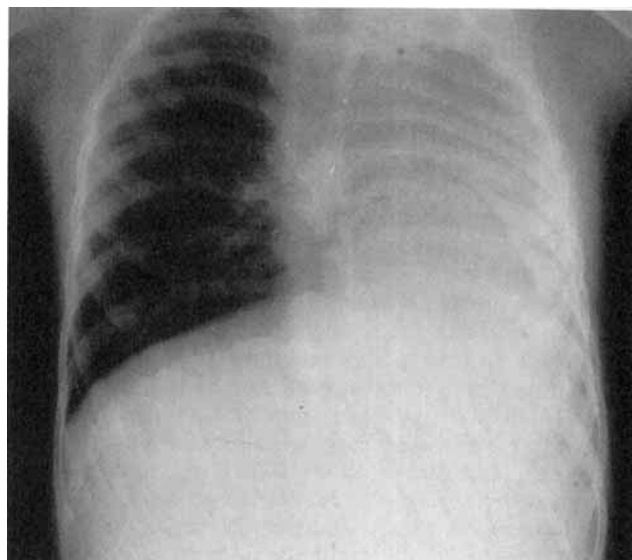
Chest X-ray: total absence of left lung.
